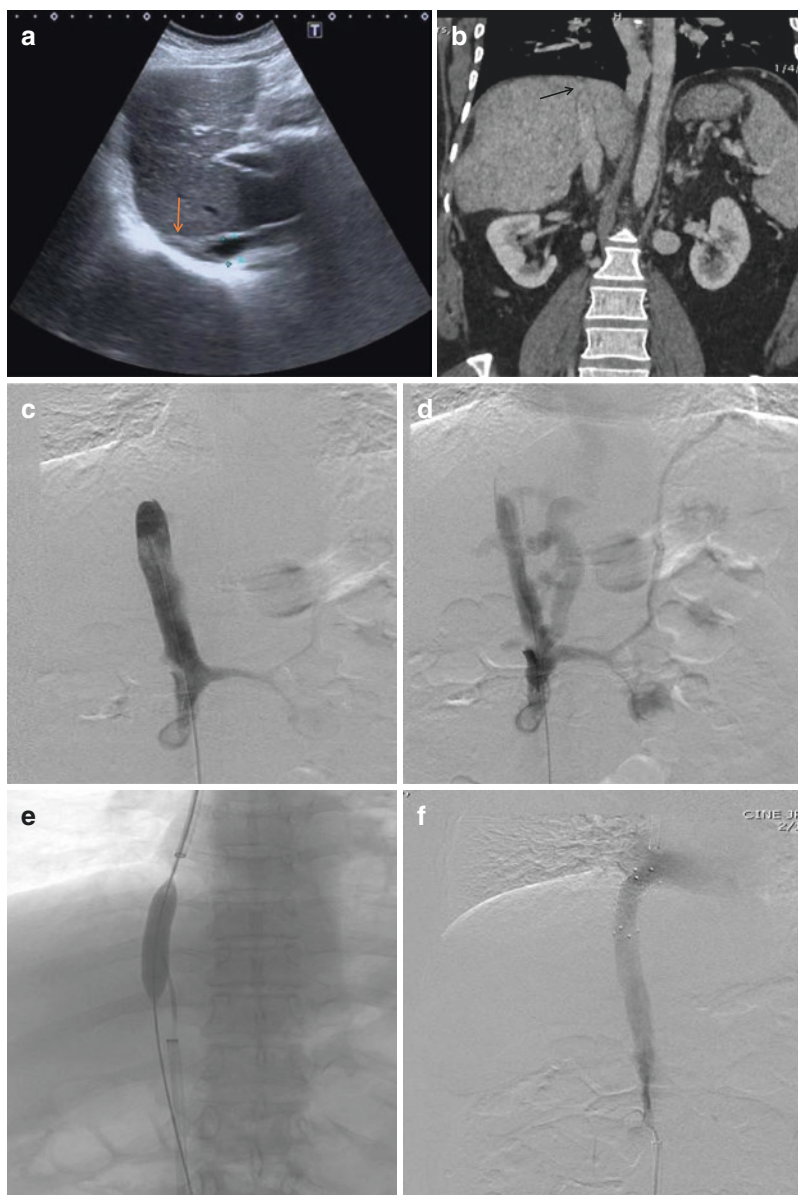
Ultrasound image (a) and contrast enhanced CT image (b) showing short segment occlusion of suprahepatic IVC below cavo-atrial junction (solid arrow in a, b). IVC gram (c) shows abrupt cut off of contrast flow and non-opacification of suprahepatic IVC with multiple collateral channel seen draining (d) diverting the flow towards the right atrium. Combined jugular and femoral approach taken to cross the occluded segment followed by balloon dilatation of the narrowed segment (e). Persistent IVC narrowing with significant pressure gradient across the narrowed segment of IVC noted hence, IVC stenting done. Post stenting venogram (f) shows free flow of contrast from IVC to the right atria with no residual narrowing
